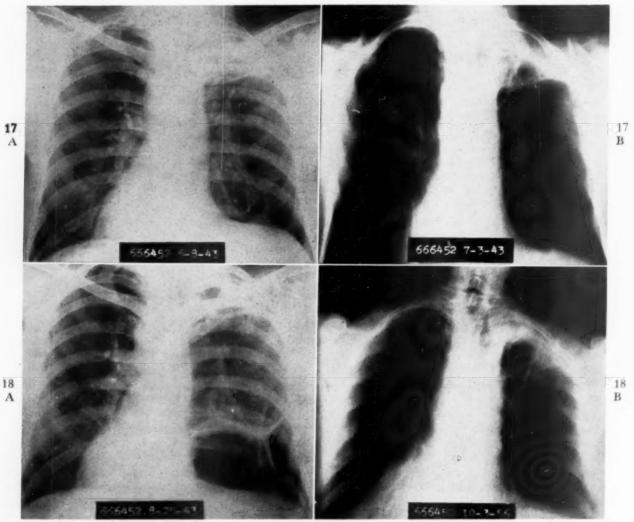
Case XII. Chest roentgenograms. A, regular anteroposterior. B, planigram showing cavitary lesion in right upper lobe.
